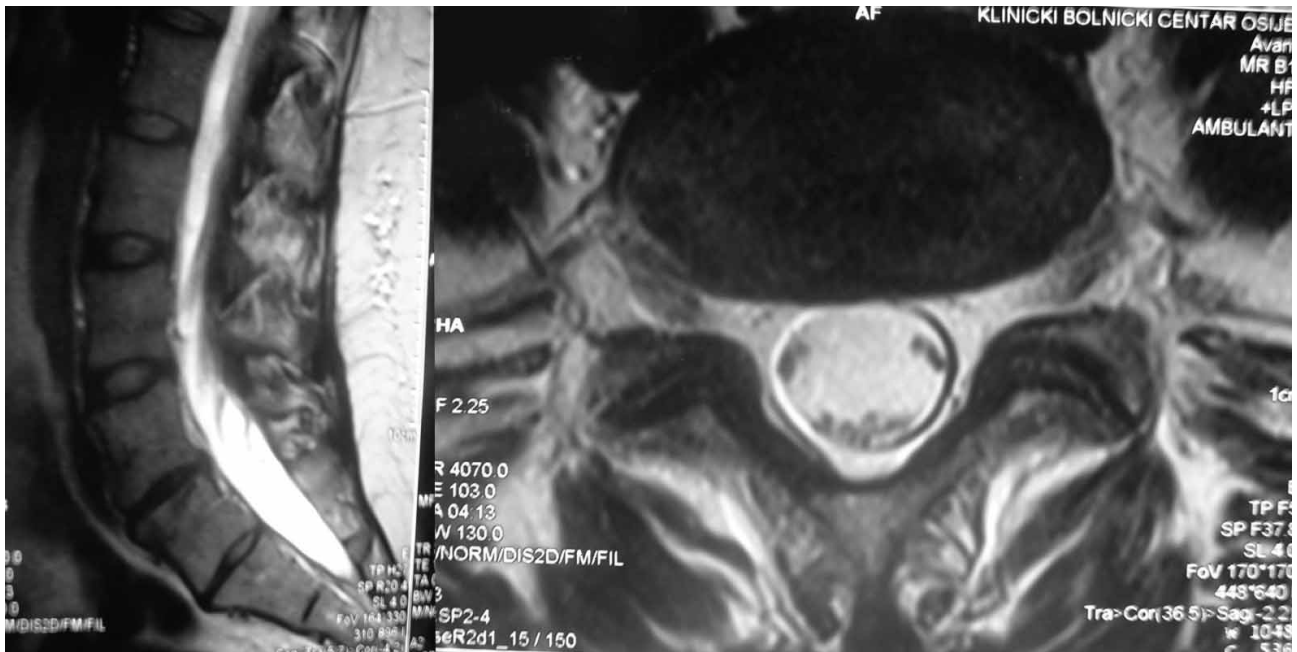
No changes in MRI taken after 24 months compared to the one taken after 12 months.
